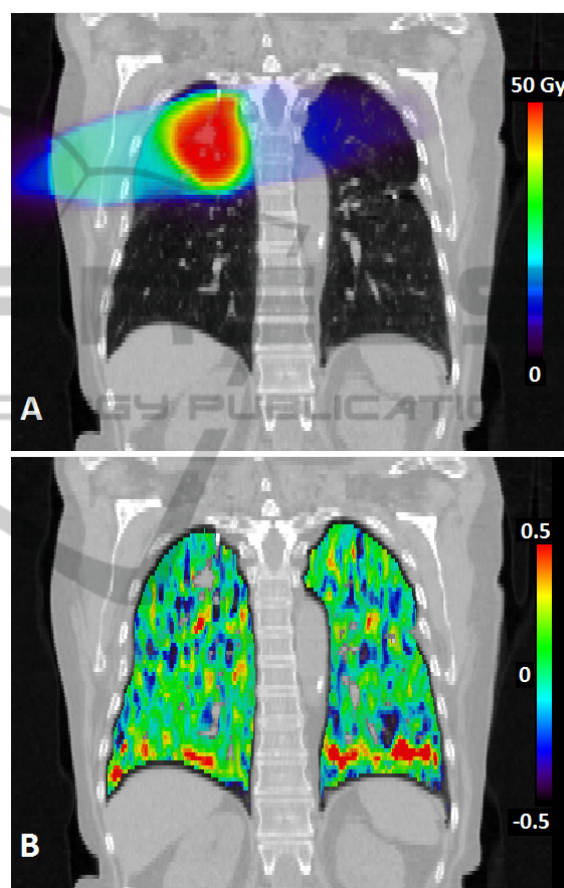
A coronal view of an example of the dose (A) and ventilation change (B) distributions overlapped with the expiration phase of the pre-treatment 4D-CT.
